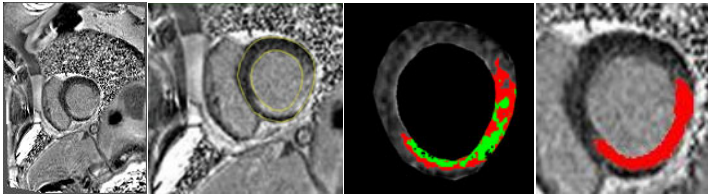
a) Original Delay enhanced SAX MR images for 3 patients b) Result of ventricular wall segmentation using level set with shape prior on background modeled images c) Segmentation of the infarct (green) and peri-infarct tissue (red) using the proposed features and k-means d) Manual contouring of the infarct tissue using ImageJ
